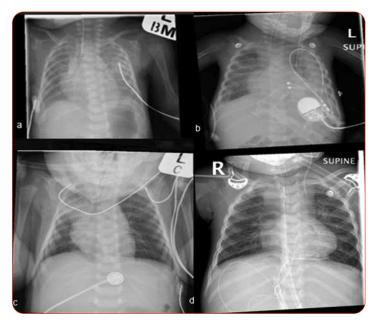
Examples from raw data on collimation practices of neonatal chest x-rays: a) improper centering resulting in uneven collimation and inclusion of non essential thoracic structures; b) under collimation resulting in inclusion of non-essential thoracic structures; c) improper positioning resulting in under collimation and overlapping of soft tissue on essential thoracic structures; d) over-collimation resulting in clipping of essential anatomic structures.
